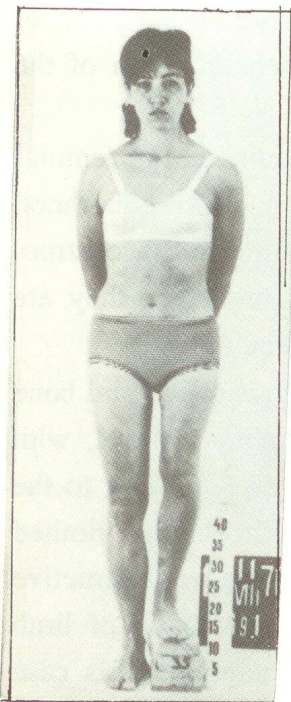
a,b. Patient and X-ray before treatment
